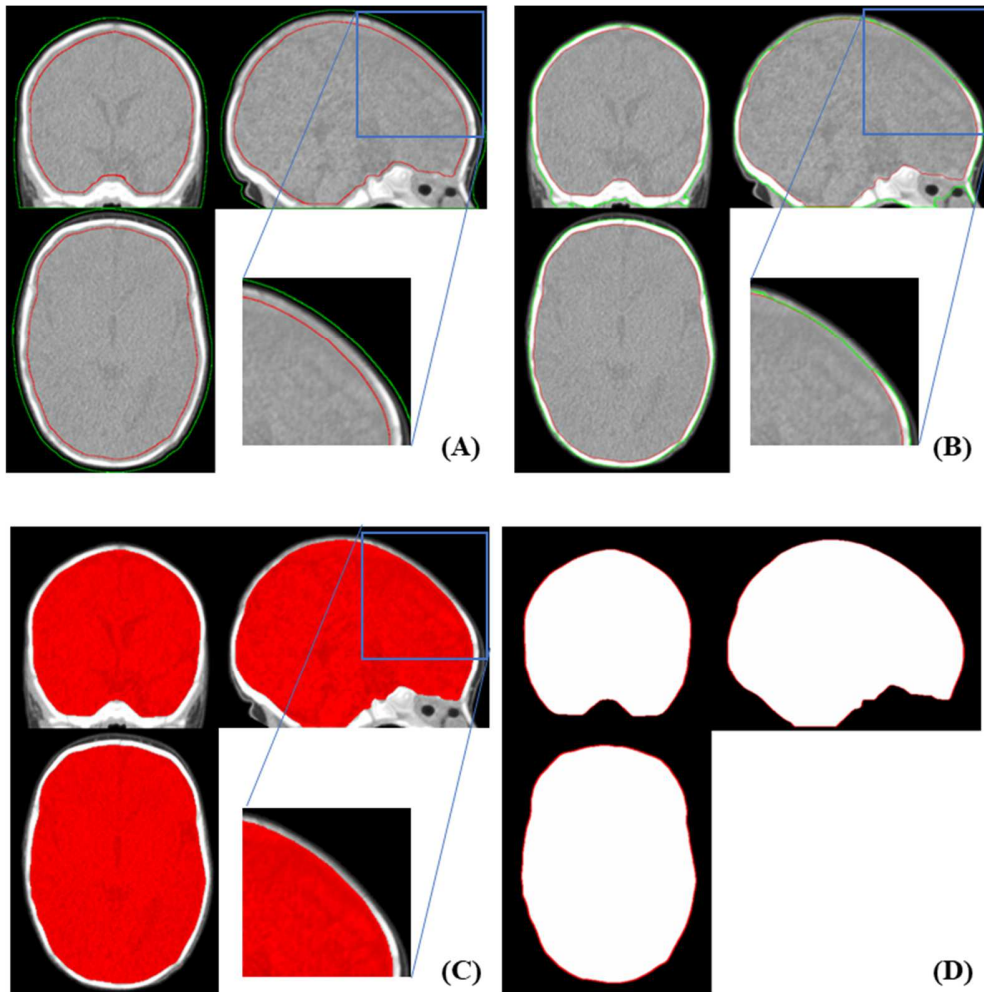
CT intracranial and skull surface extraction using the coupled level sets method described in [5]. (A) The initial interior (red) and exterior (green) surfaces. (B) The extracted inner and outer borders of cranial bones and reconstructed fontanels and sutures (C) Corresponding mask of the resulting interior contour using filling operator overlaid on the CT image. (D) The extracted intracranial mask; its volume is reported as intracranial volume.
